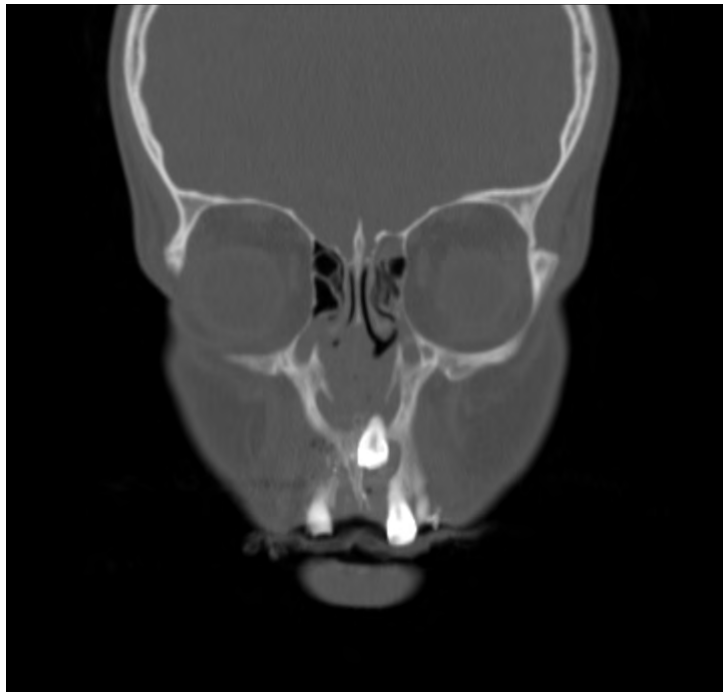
Post-traumatic CBCT image.
